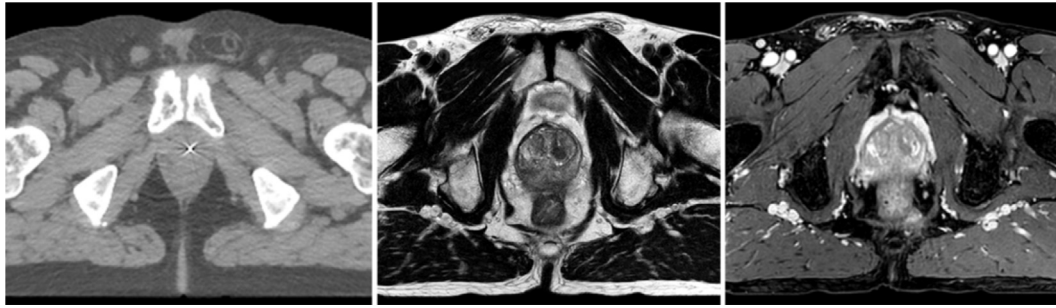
Comparison of axial CT (left), two-dimensional (2D) T2-weighted fast spin echo MRI (centre) and 3D balanced fat-suppressed gradient-echo MRI sequence (centre and right) images used in UMC Utrecht for treatment planning. In the MRI image, the internal structure of the prostate is readily apparent, while on CT bones and the intraprostatic fiducial marker are clearly visible. The figure has been reproduced from [8] with the author's permission.
